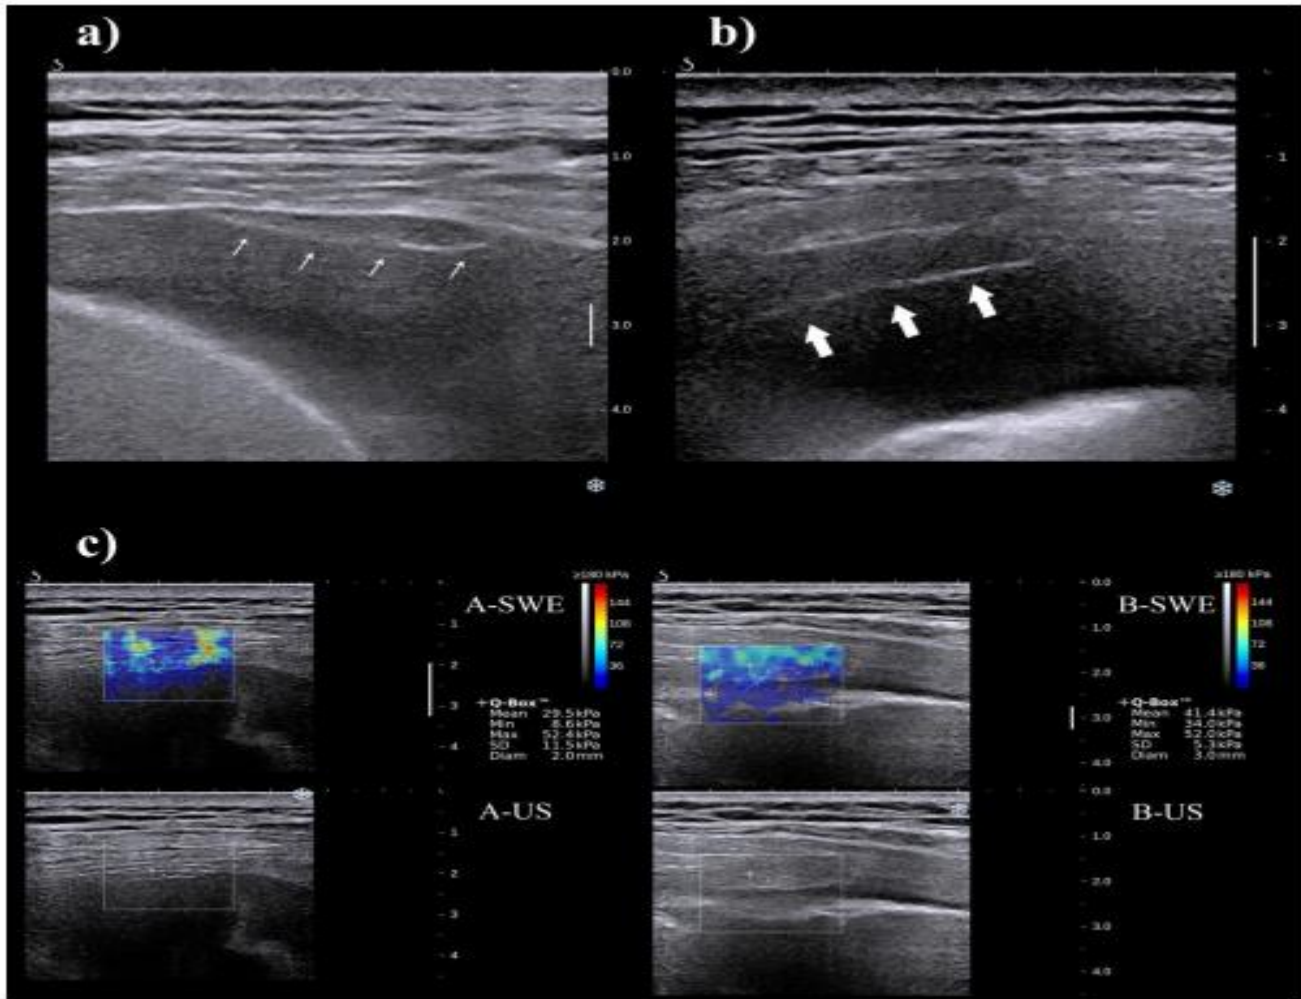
Ultrasound features of pleural nodules and focal pleural thickening and measurements of pleural stiffness by shear wave elastography. Pleural nodules appeared as hypoechoic nodular lesions with defined margins located in the parietal or visceral pleura (a), while focal pleural thickening was identified as an echogenic area of increased thickness in the parietal pleura with poorly defined margins (b). Images of pleural thickening or nodules are displayed together with the grayscale ultrasound images. After placing a box (frame) over the pleura, a colored image appeared, revealing blue and red areas on an elastogram. Dark blue areas correspond to soft tissues, whereas red areas correspond to stiff tissues (c) [32].
